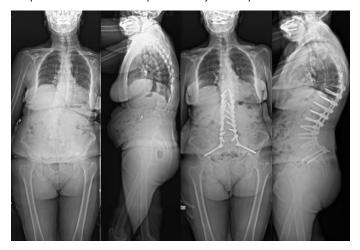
Standing preoperative/postoperative (2 year after surgery) radiographs in the anteroposterior and lateral projections of a 71-year-old woman who underwent a posterior instrumented fusion from T10-ilium (S2AI). In the 2-year period, preoperative LL improved from 21° to 56° and SVA decreased from 45 mm to 16 mm
